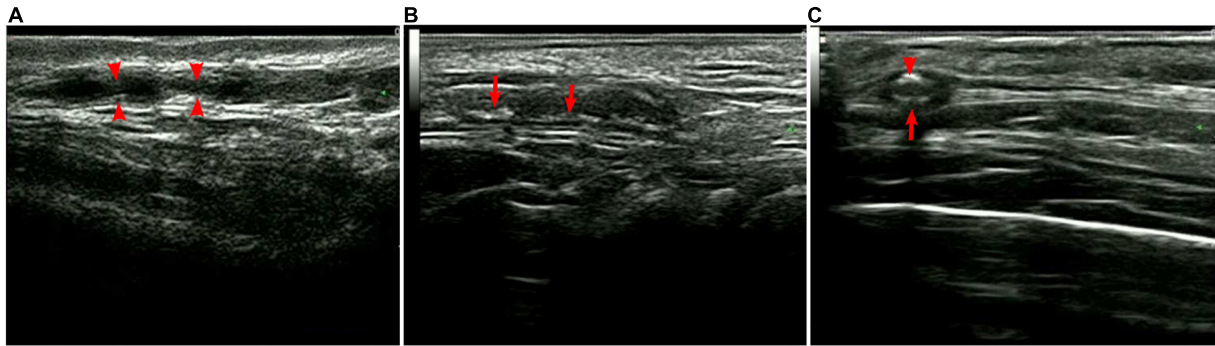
Superficial temporal artery ultrasound. (A) Segmental stenosis (arrows); (B) segmental thickening with calcification (arrows), and (C) hypoechoic halo (large arrow) with calcification (small arrow).
